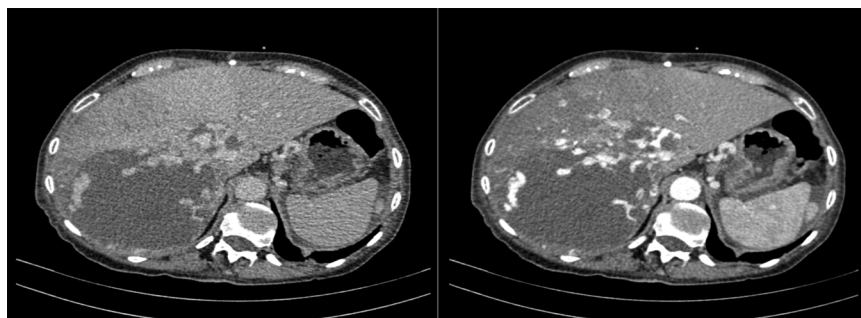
Liver recipient abdominal computed tomography revealing hypodense expansive lesions, with peripheral vascular enhancement, disseminated by the right lobe.
